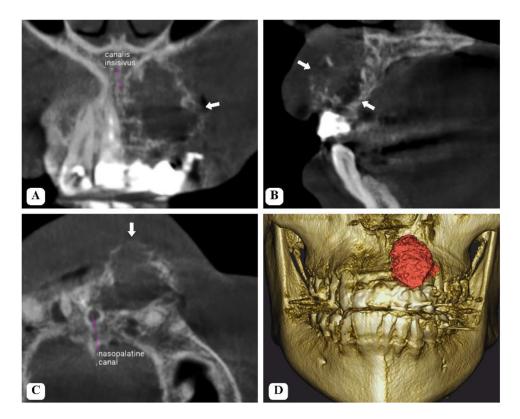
Case 1, Multiplanar reformation (MPR) CBCT images. (A) coronal view, (B) sagittal view, (C) axial view, (D) 3D view with lesion segmentation.
